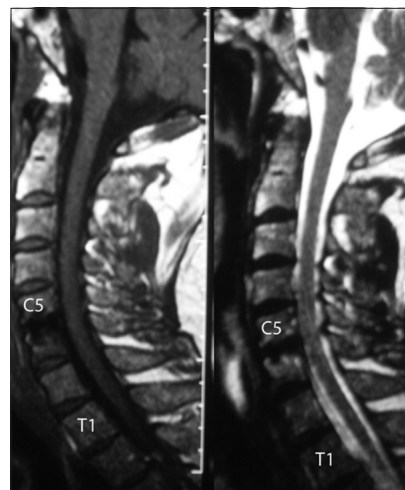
Postoperative imaging of the cervical spine of the patient. At sagittal T1-weighted magnetic resonance imaging (MRI) (left) and sagittal T2-weighted MRI (right), resolution of the syringomyelia is evident.
